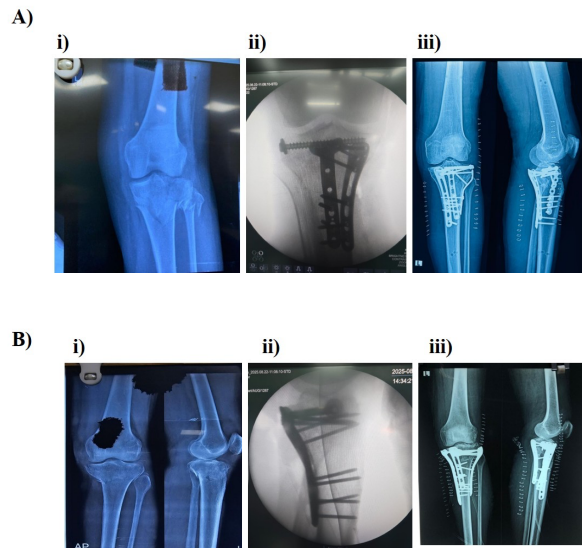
A) and B): (i) Radiographs of Preoperative anteroposterior, (ii) images of Intraoperative fluoroscopic and, (iii) anteroposterior and lateral views of Postoperative radiographs
